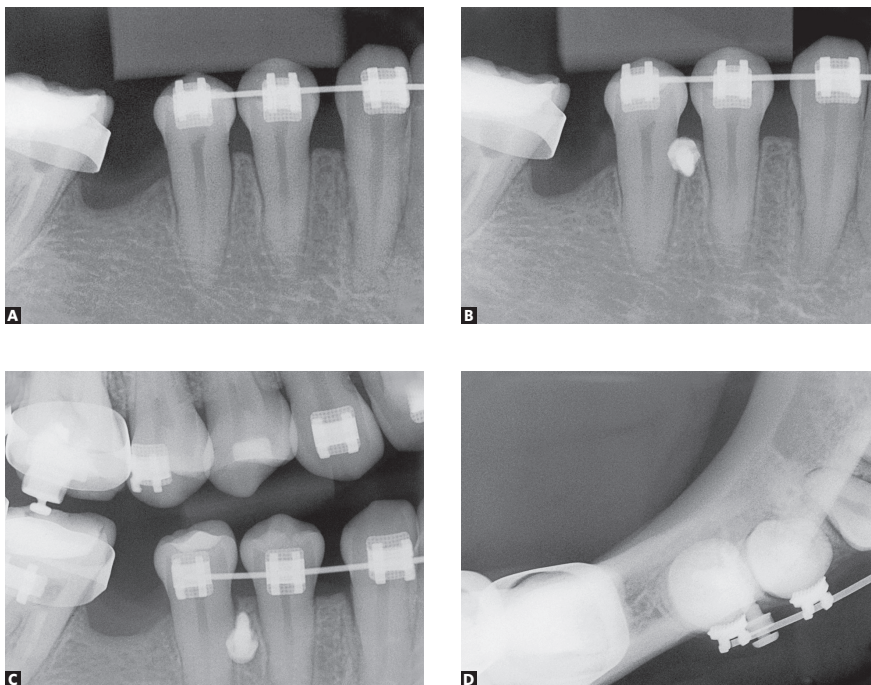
A) Initial periapical radiograph; B) Periapical radiograph after implant placement; C) Bitewing radiograph; D) Conventional occlusal radiograph.
